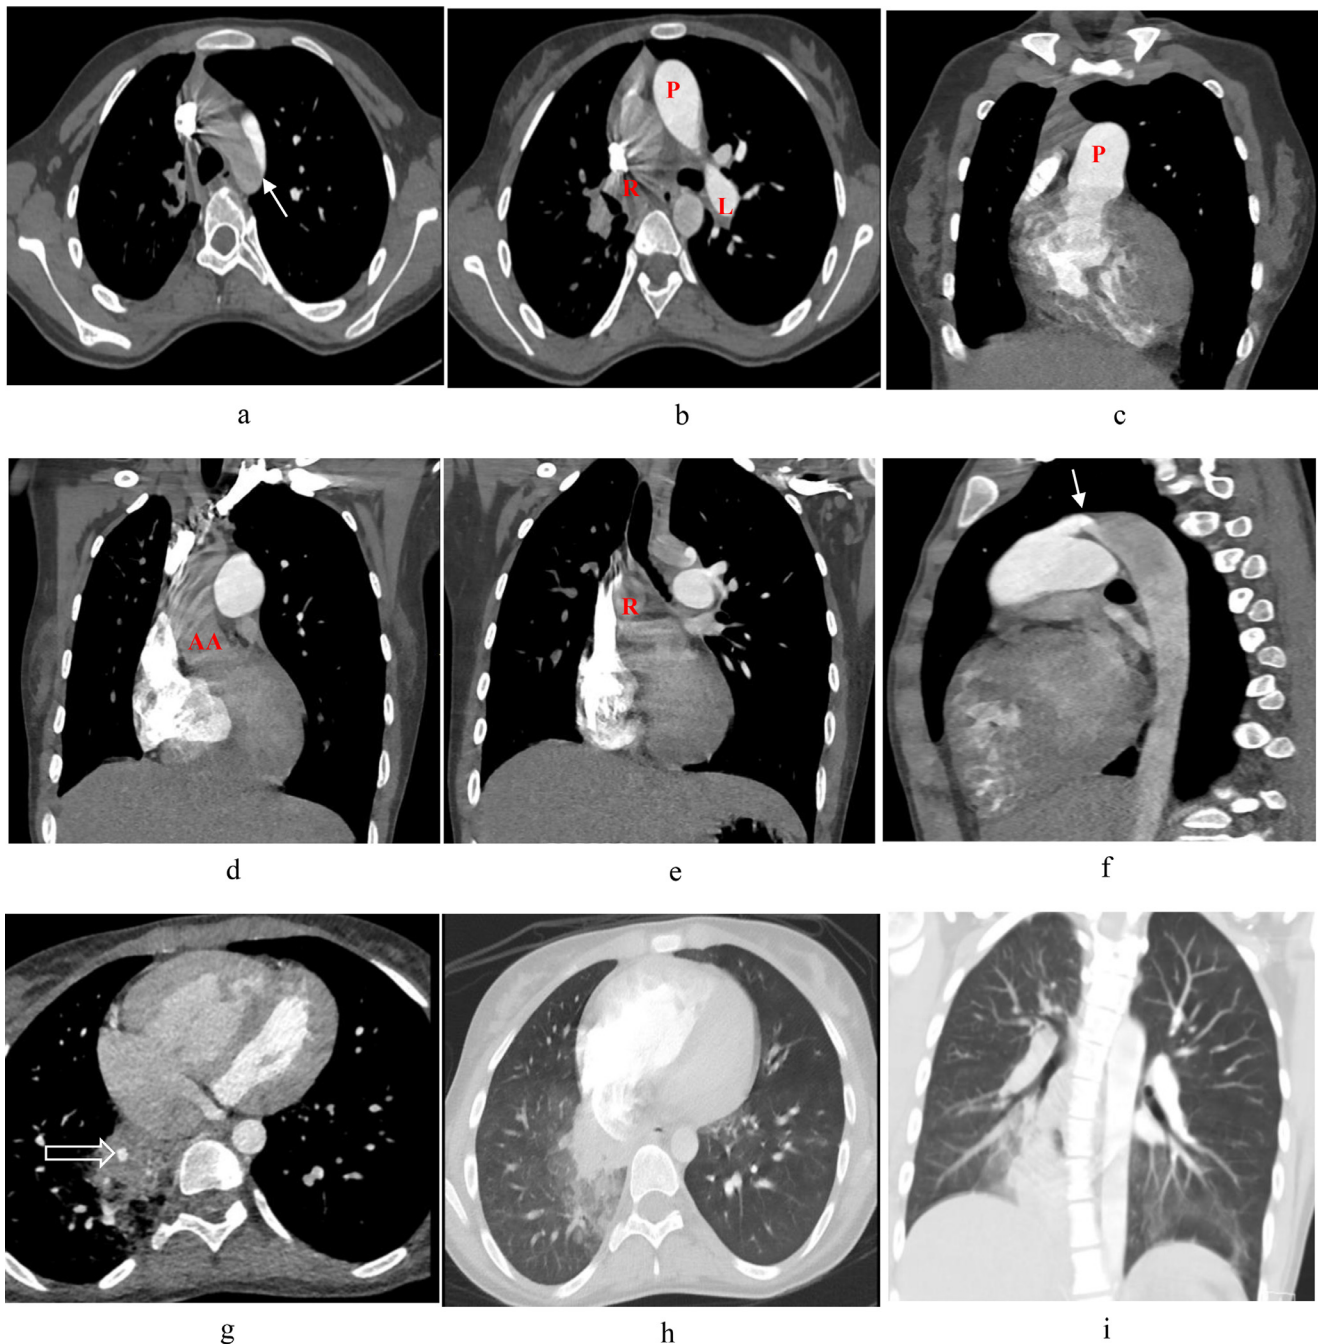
Axial (a-c), coronal (d-e) and sagittal (f) chest CT scan with intravenous contrast shows normal opacification of pulmonary trunk [P] and left pulmonary artery [L]. Right pulmonary artery [R] is not opacified with contrast, it's likely originated from the ascending aorta [AA] causing mass effect and narrowing of the right main bronchus. Patent ductus arteriosus (white arrow) is seen connecting between pulmonary trunk and aortic arch (a, f). Magnified axial (g) chest CT scan shows segmental pulmonary aneurysm [empty arrow head] within the right lower lobe. Axial (h) and coronal (i) lung window demonstrate irregular consolidation of the medial segment of right lower lobe, surrounded by ground glass opacities.
